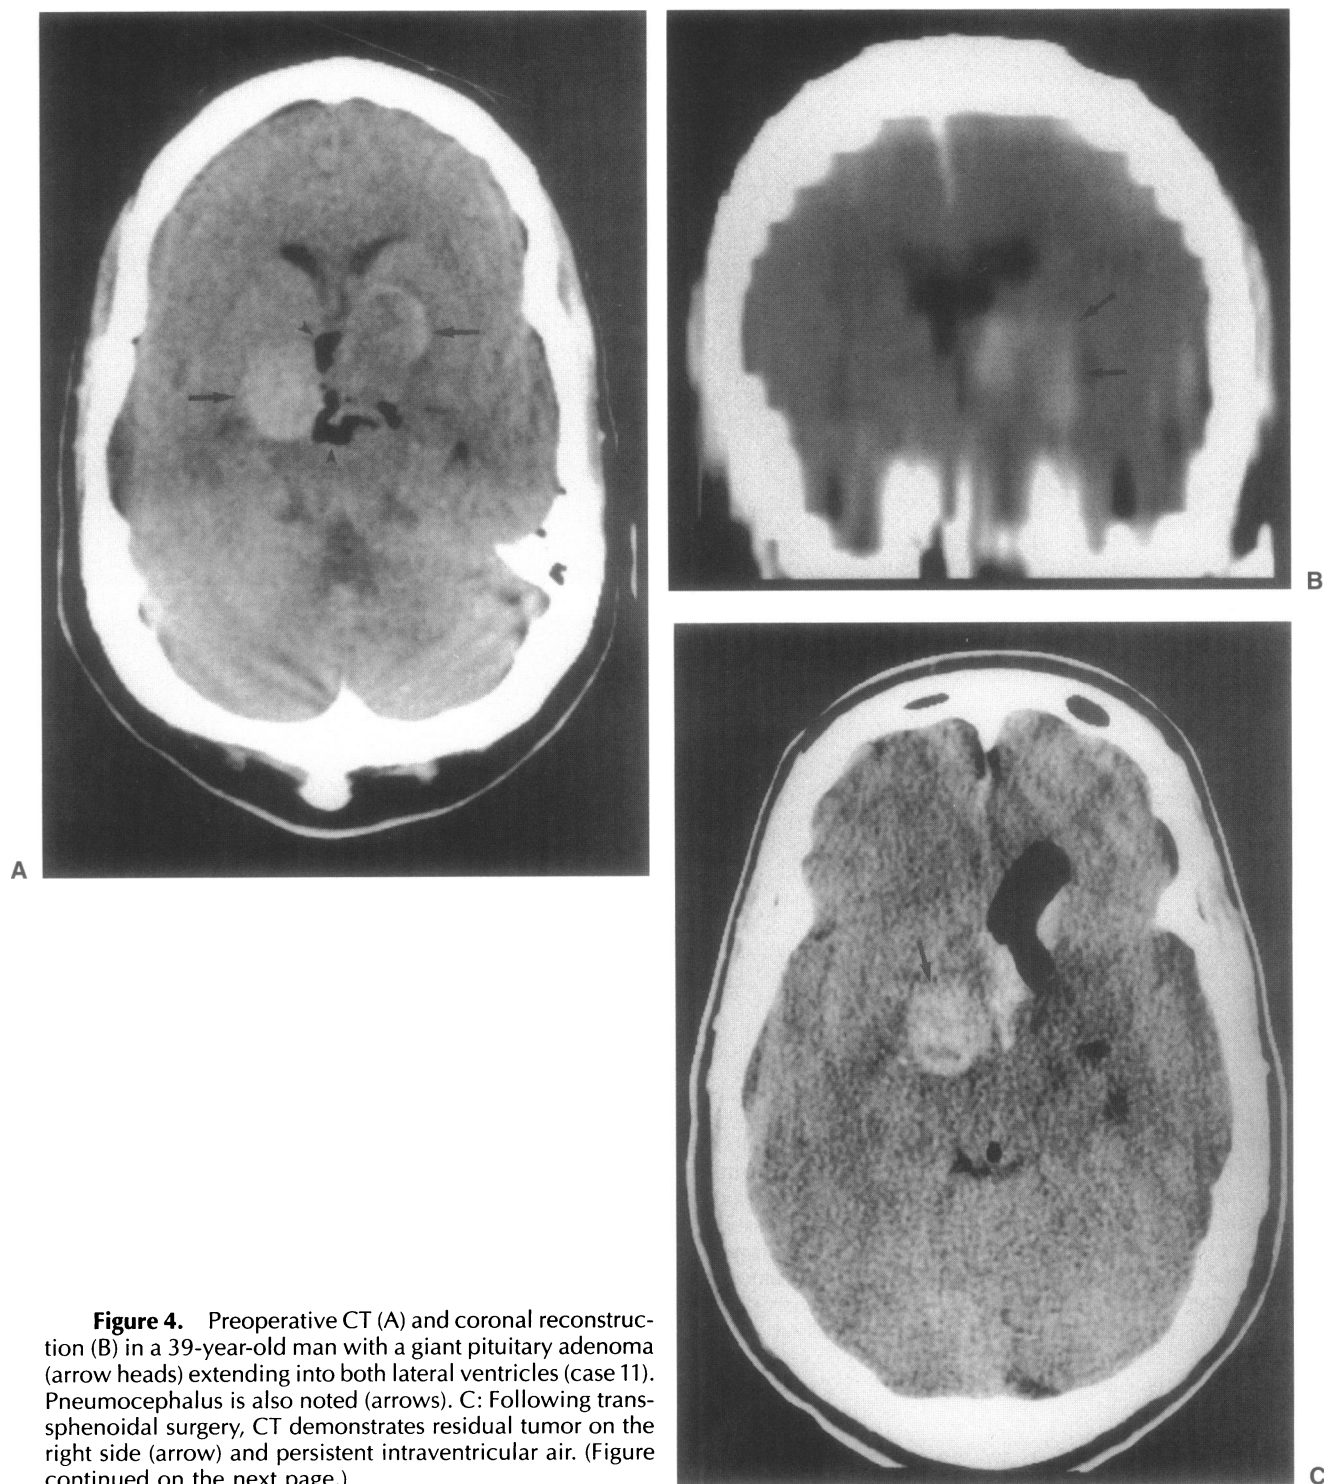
Preoperative CT (A) and coronal reconstruction (B) in a 39-year-old man with a giant pituitary adenoma (arrow heads) extending into both lateral ventricles (case 11). Pneumocephalus is also noted (arrows). C: Following transsphenoidal surgery, CT demonstrates residual tumor on the right side (arrow) and persistent intraventricular air. (Figure continued on the next page.)
